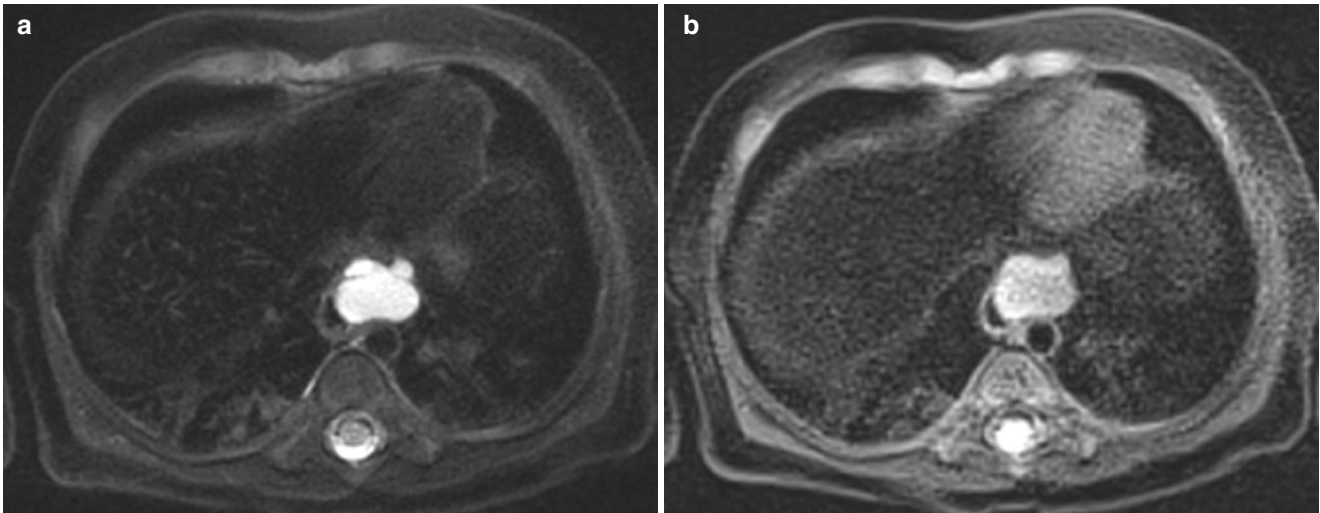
(a, b) MRI of the chest. Axial T2-weighted image with fat saturation (a) and T2 post-gadolinium image (b) demonstrate a T2 bright cystic structure arising from the anterolateral wall of the esophagus, suggestive of esophageal duplication cyst
